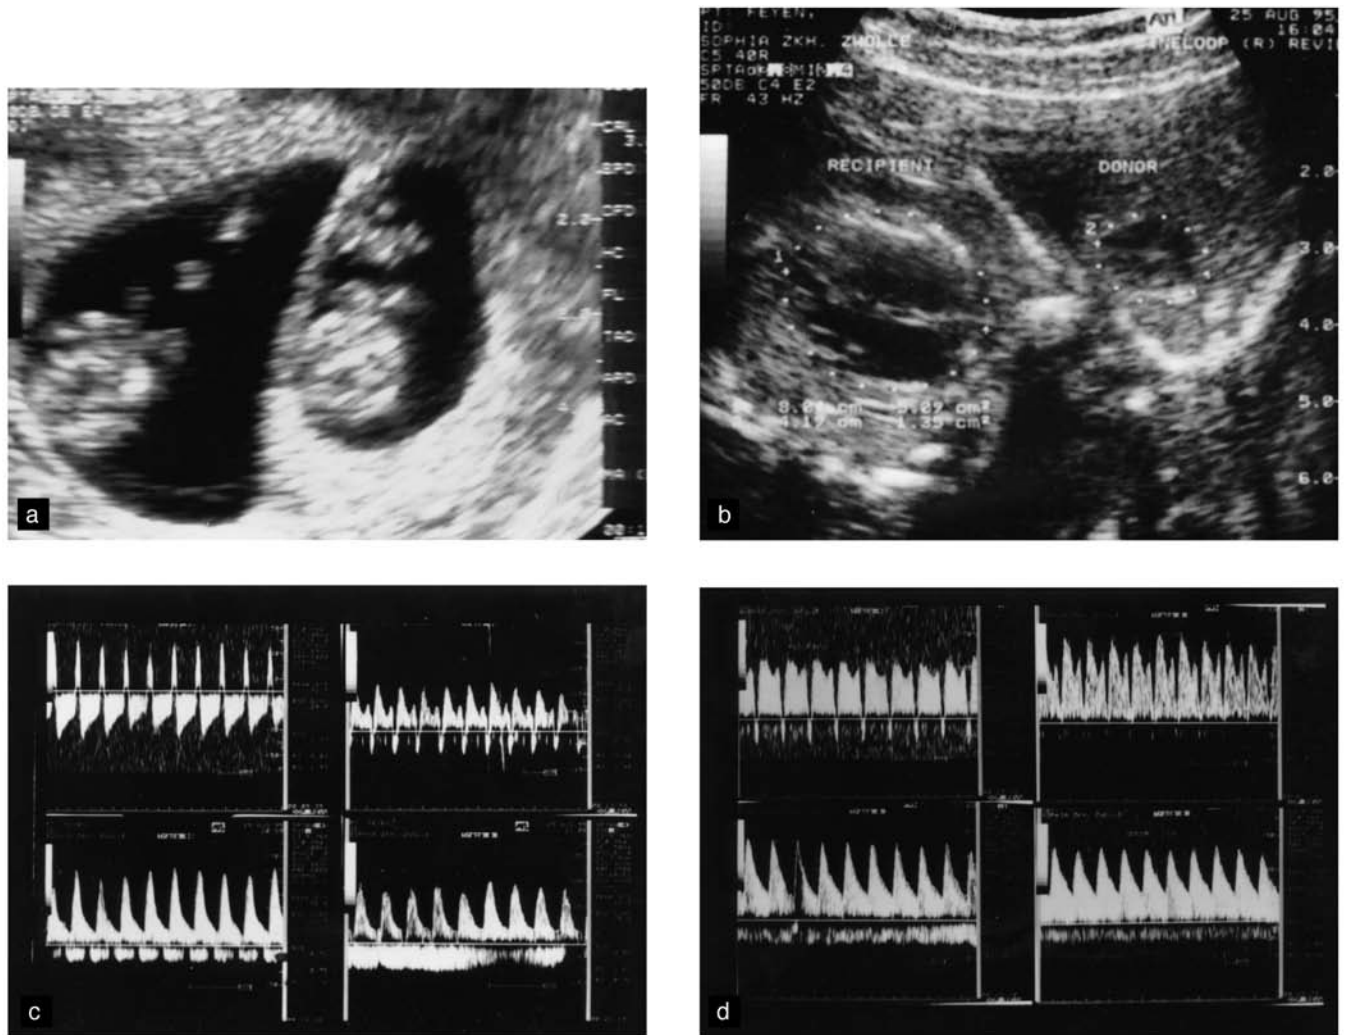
Ultrasound pictures of pathologic early twin gestation. (a) Early growth difference in a dichorionic twin pregnancy at 10 weeks (triploidy xxx). (b) Early TTTS at 16 weeks with hydrops of the recipient twin (left), there is evident inter-twin difference in cardiac dilatation. (c) Doppler flow velocity wave forms of the ductus venosus (above) and the umbilical vessels (below) of recipient (left) and donor twin (right) before treatment. (d) Doppler flow velocity wave forms of the ductus venosus (above) and the umbilical vessels (below) of recipient (left) and donor twin (right) after treatment.
